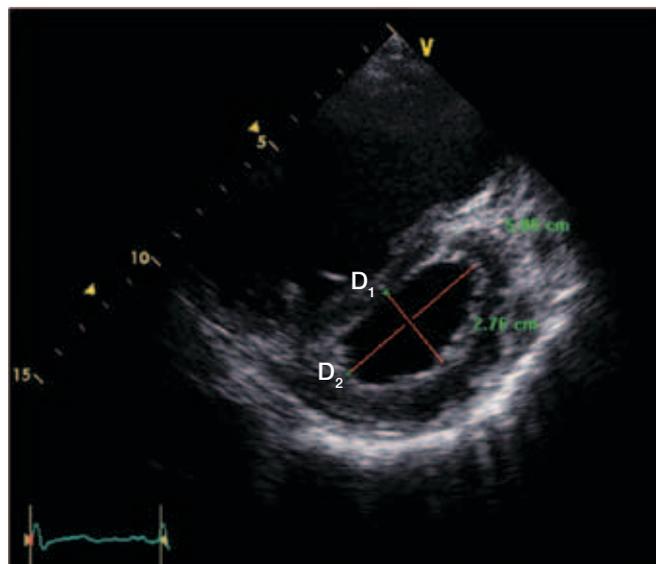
The LV diastolic eccentricity index (EI) is measured from the parasternal short axis view at the level of the papillary muscles at end-diastole. The LV cavity is measured parallel to the IVS (D₂) and perpendicular to the IVS (D₁). The diastolic EI in this example is:
